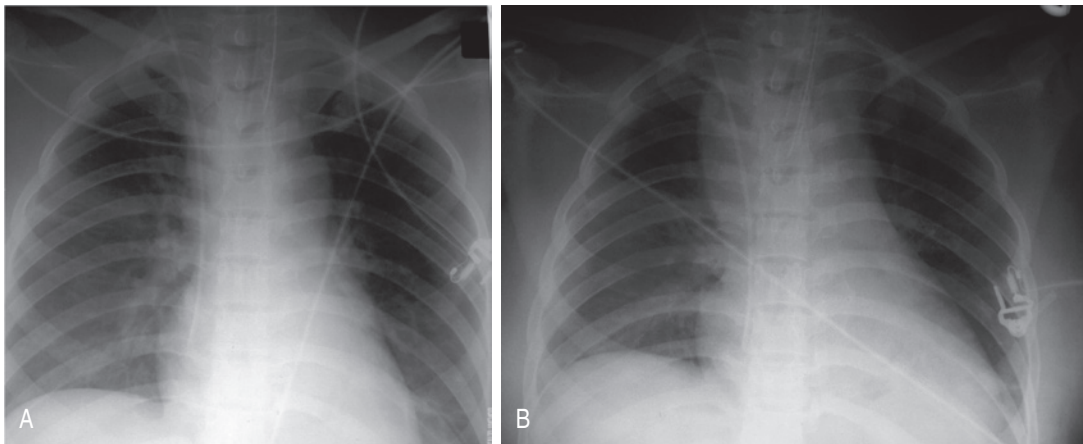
Following cardiac surgery (a) the postoperative chest radiograph appears satisfactory. A few hours later (b) the mediastinum has widened considerably due to mediastinal haemorrhage.
